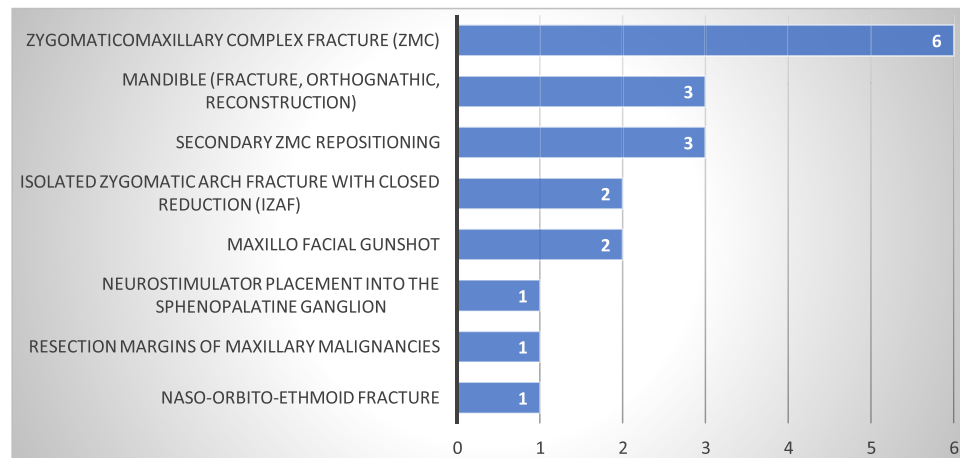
Number of articles according to the clinical indication for intraoperative CBCT in maxillofacial surgery.
